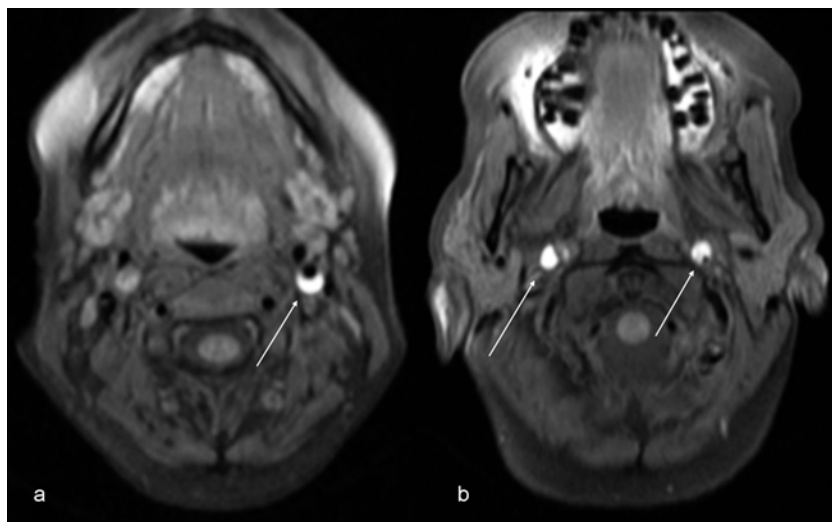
Fat suppressed axial MR images: a: Proximal dissection of the left internal carotid artery, b: Distal bilateral internal carotid artery dissections.
